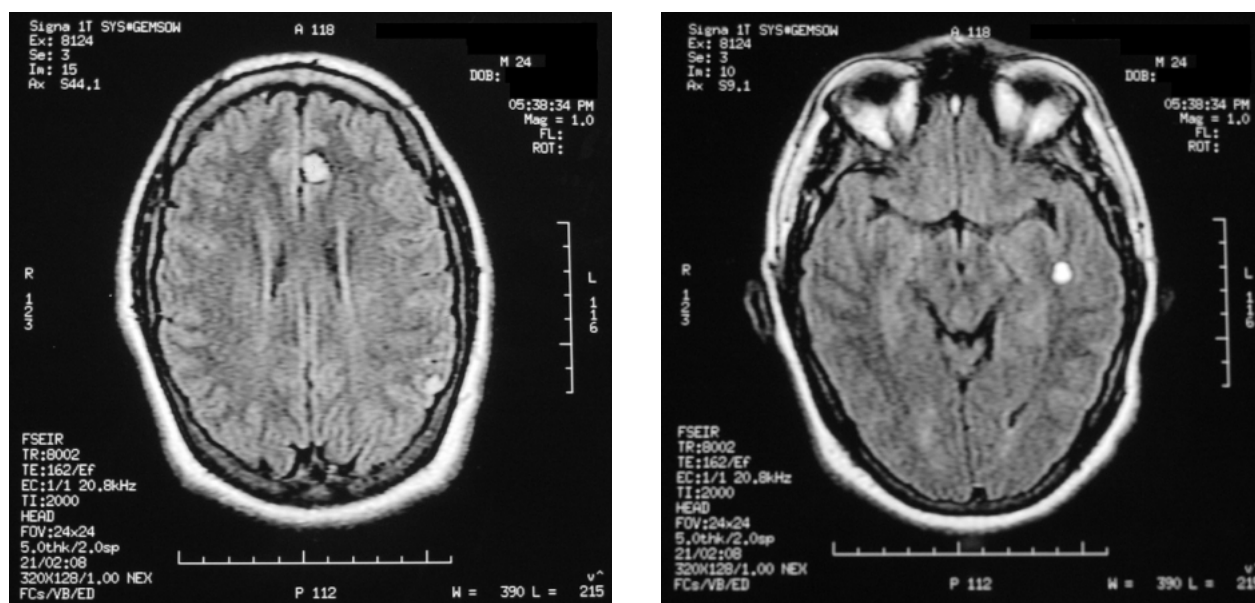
Fluid attenuated inversion recovery (FLAIR) magnetic resonance images of the case patient's brain. (Left) Well-defined, round/elliptical masses with fluid signal characteristics without mass effect are visible. (Right) An elliptical intra-axial mass with a central, slightly hyperintense signal and a peripheral hypodense signal is visible. No surrounding vasogenic edema is present.
